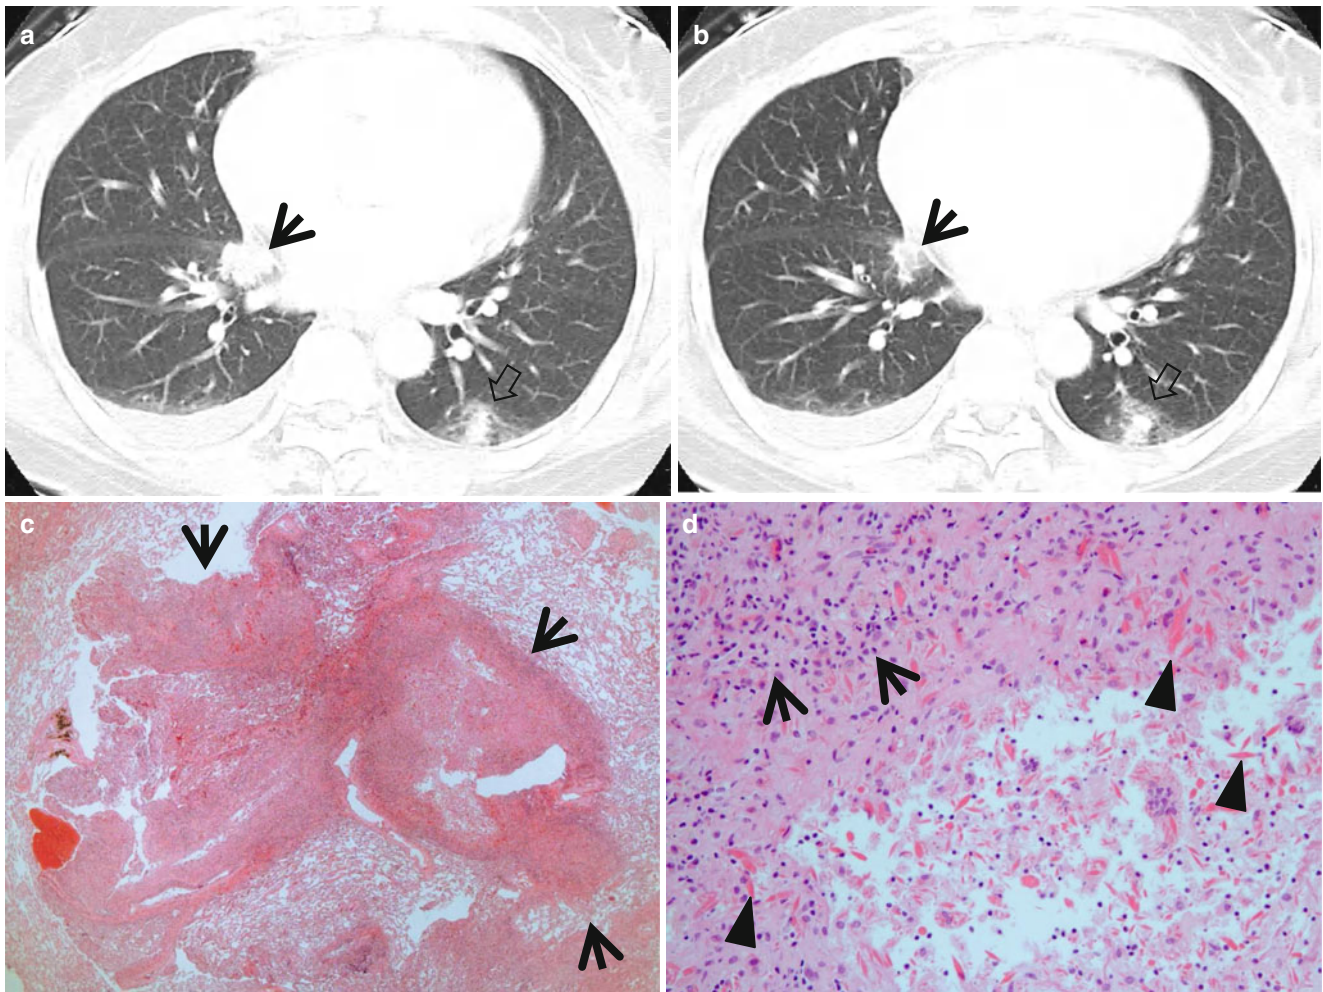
Loeffler's (pulmonary infiltration with eosinophilia, PIE) syndrome in a 50-year-old woman. (a, b) Lung window of consecutive CT scans (5.0-mm section thickness) obtained at levels of the inferior pulmonary veins shows a nodule (arrows in a and b) in medial basal segment of the right lower lobe and a nodule and halo sign (open arrows in a and b) in superior segment of the left lower lobe.
